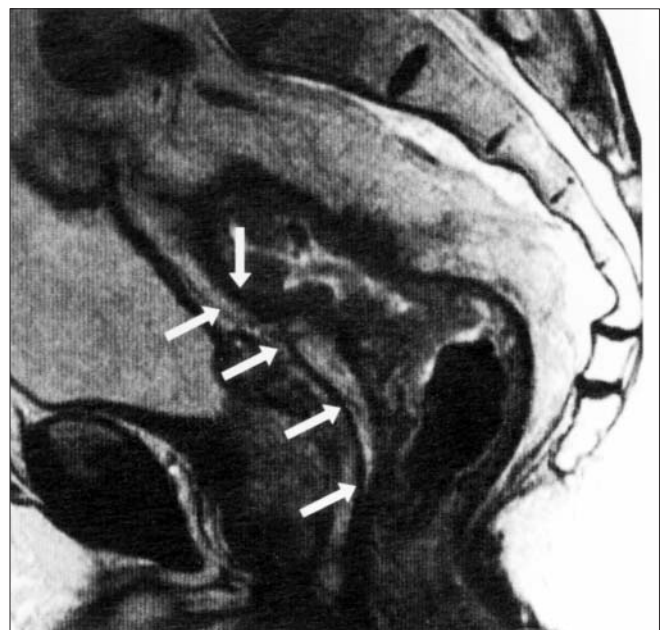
Magnetic resonance image demonstrate Denonvilliers fascia
